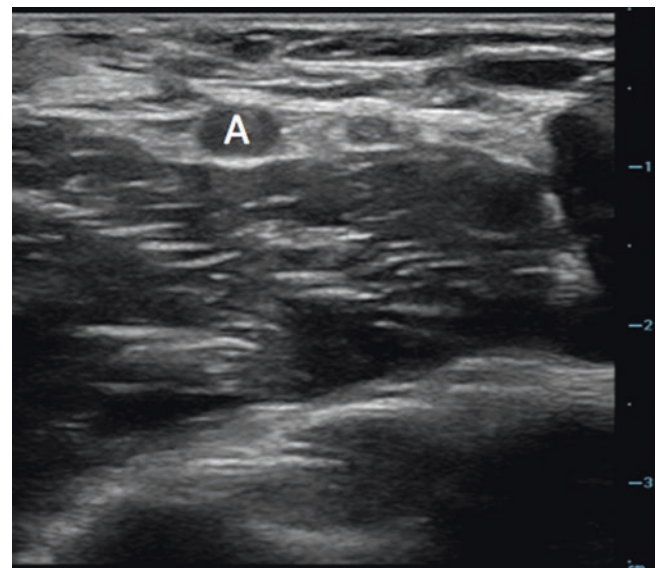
Ultrasound image of the right antecubital fossa under compression. Veins have thin compressible walls, whereas arteries (A) have thicker walls that do not fully compress upon application of pressure. Image courtesy of Stephen Alerhand
